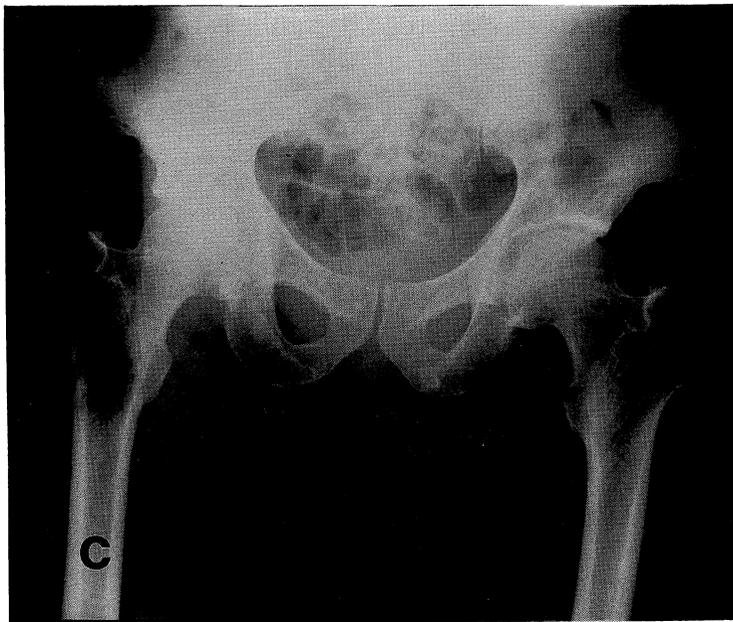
Bone radiography showed osteolytic change in the right femur.
